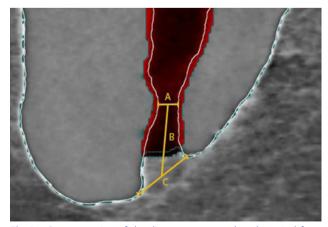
Representation of the distances measured at the apical foramen region using micro-computed tomography. (a), a narrow diameter of the physiological foramen. (b), distance between the physiological and anatomical foramen. (c), diameter (width) of the anatomical foramen (7).
